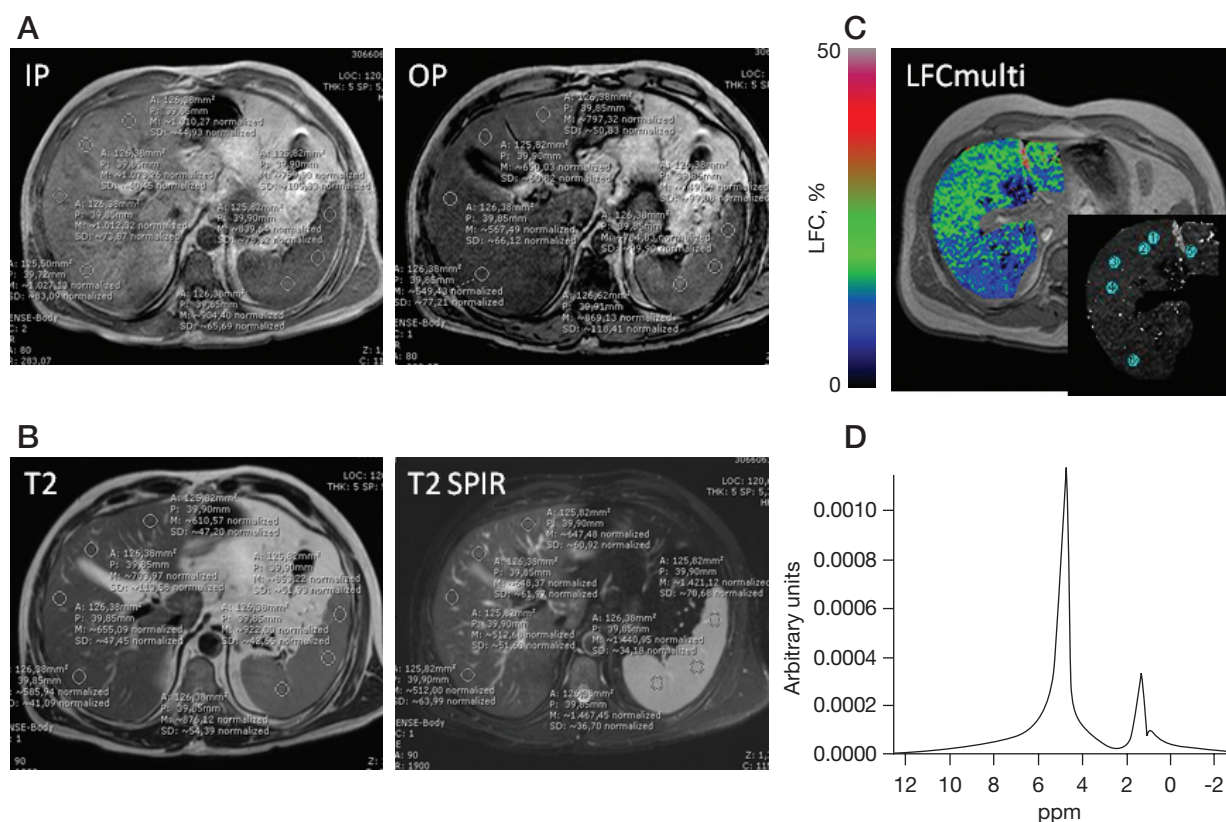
Images were reviewed with Synapse (Fujifilm USA Medical Systems, Fujifilm, Tokyo, Japan). The signal intensity (SI) values of liver and spleen were recorded on IP and OP T1-weighted MR images and T2-weighted MR
